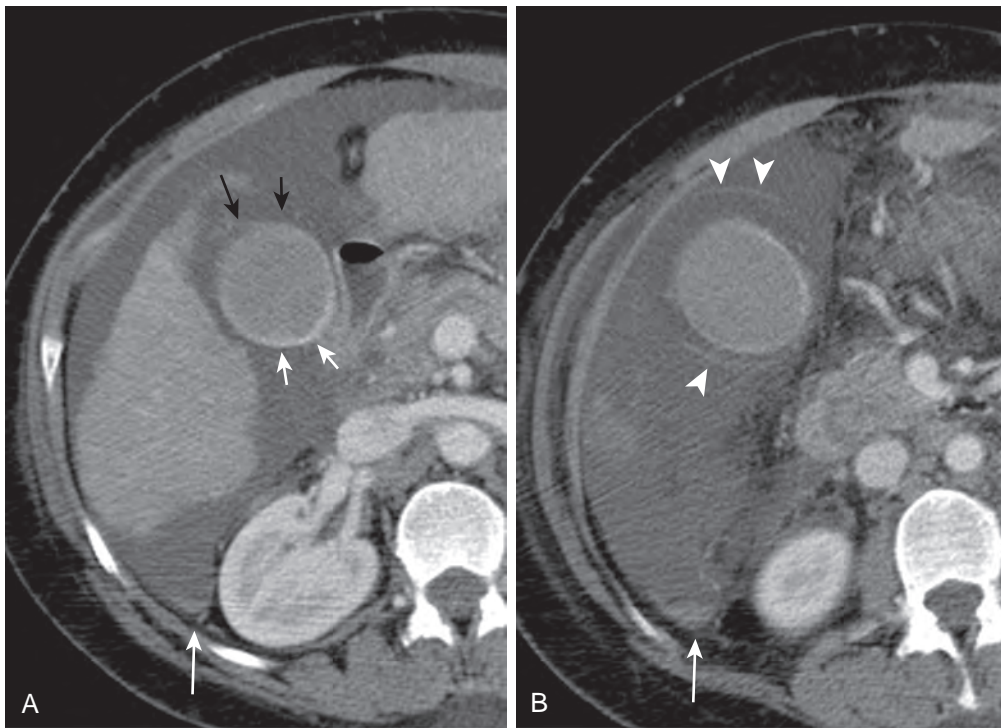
Gallbladder avulsion. Alcoholic patient with cirrhosis after motor vehicle accident. A. Contrast-enhanced CT shows inhomogeneous enhancement of the gallbladder, with hypoenhancing (black arrows) and hyperenhancing areas (short white arrows). B. A thin membrane (arrowheads) surrounds the gallbladder, strongly suggesting the diagnosis of gallbladder avulsion, a finding confirmed at laparotomy. Moderate ascites, primarily secondary to cirrhosis. The hematocrit effect (long white arrow, A and B) in right paracolic gutter reflects component of hemoperitoneum.
